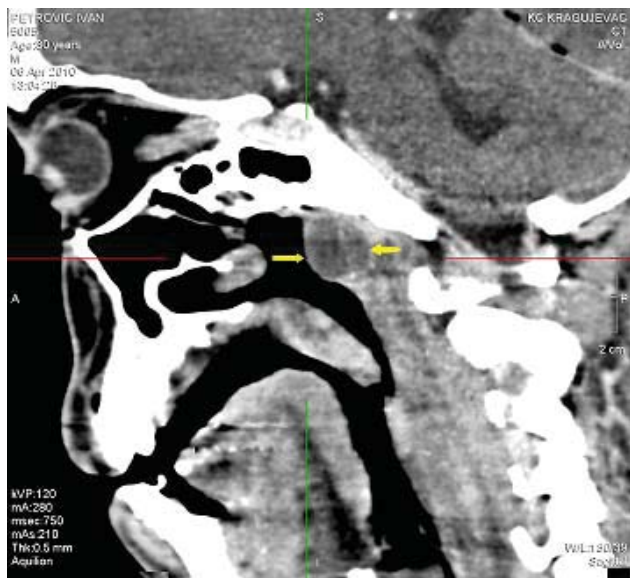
Computed tomography (CT) reveals retropharyngeal hypodense lesion, 24 × 18 mm in diameter, at the level of nasopharynx
